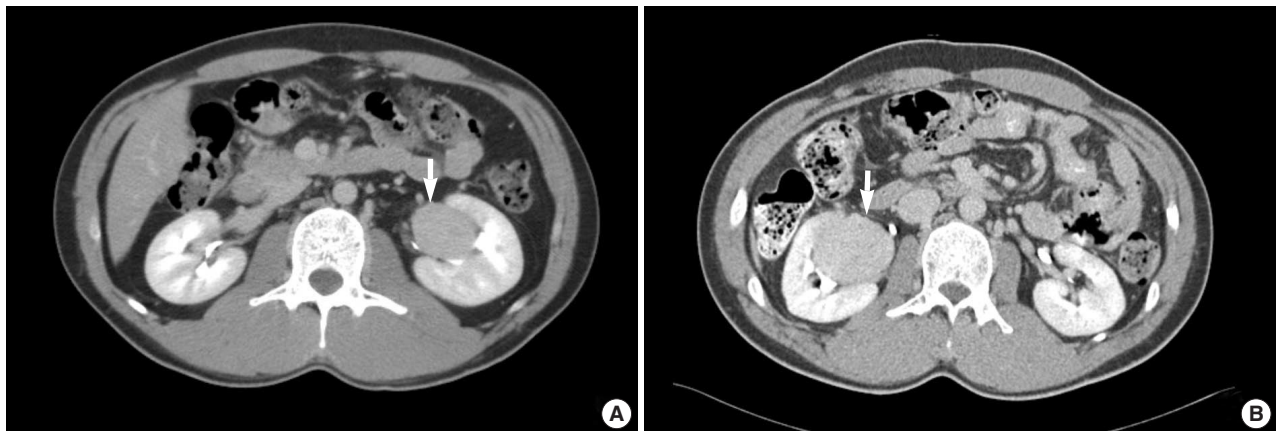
Abdominal computed tomography scan in delayed phase. (A) Well-circumscribed mass with homogeneous density is located in the left kidney in case 1 and (B) in the right kidney in case 2.
